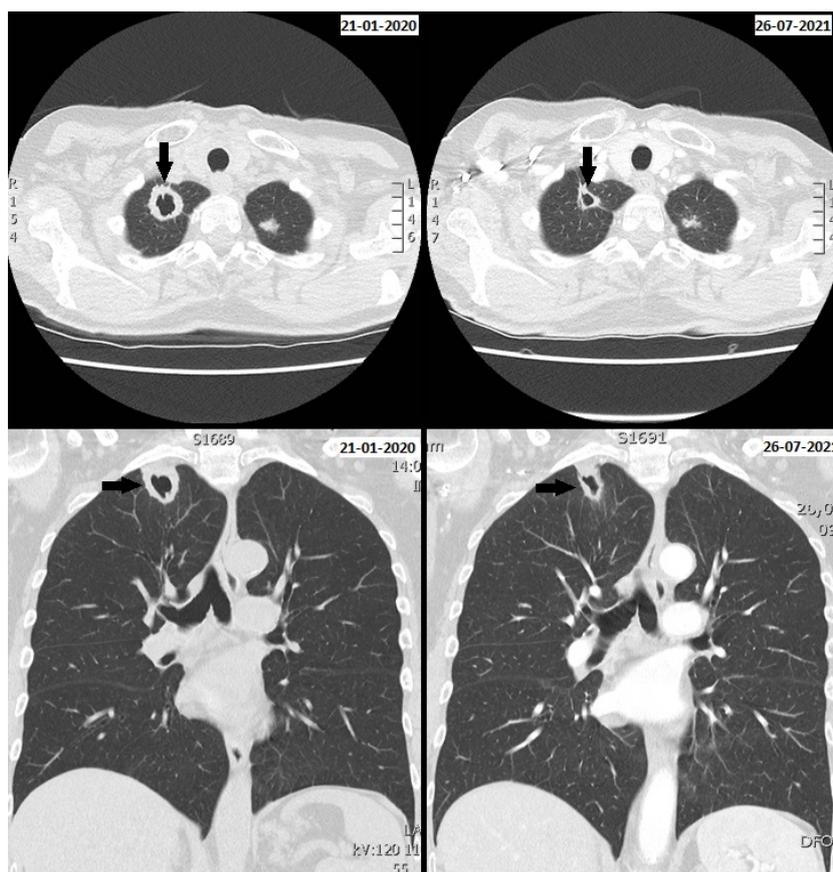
Left side: Chest CT before treatment showing the mass in the right upper lobe with central excavation (arrow). Right side: Chest CT showing reduction of the mass in the right upper lobe (arrow) after one year of treatment with infliximab.
